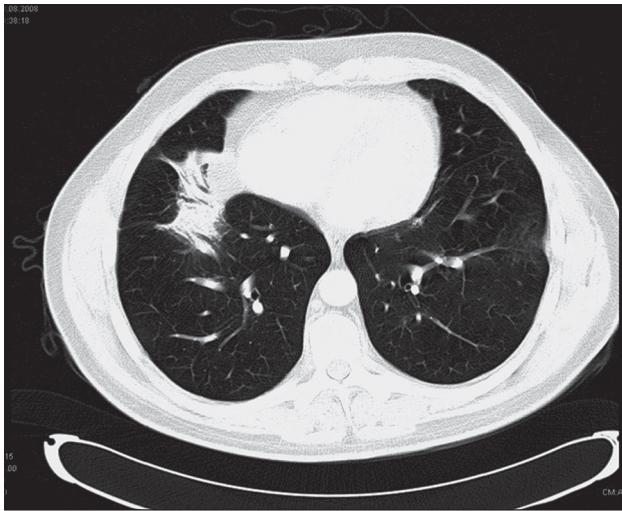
CT scan of lungs. Consolidation of lung parenchyma with bronchogram
